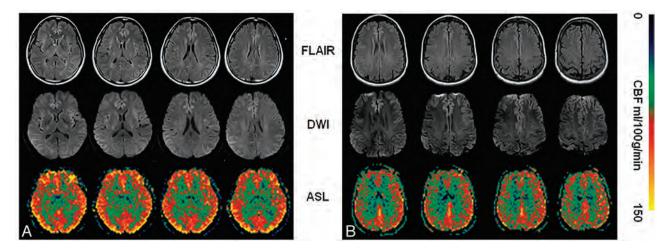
Representative cases from the control cohort. *A*, A 50-year-old woman was evaluated for dizziness after an automobile crash. No specific findings are reported on the standard MR, DWI, and MRA tests. ASL reading scores are rated 1, 1, 1 by 3 raters. *B*, A 49-year old woman was evaluated for a chronic headache of unknown cause. No specific findings are reported on the standard MR, DWI, and MRA tests. ASL reading scores are rated 2, 2, 2 by 3 raters.
